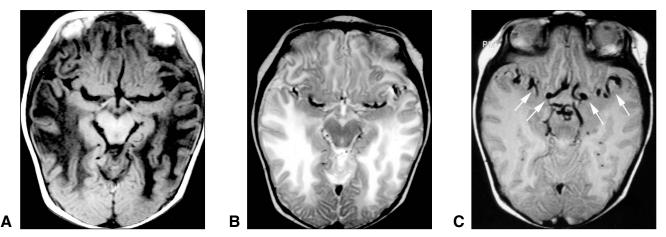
a) T1-weighted and *b)* T2-weighted brain MRI of four-month-old infant with Menkes Disease, showing atrophy and impaired myelination, with abnormal hypointense T1 and hyperintense T2 signal in the white matter of both frontal and temporal lobes. c) Axial Proton Density weighted brain MRI, with arrows showing tortuous blood vessels.
